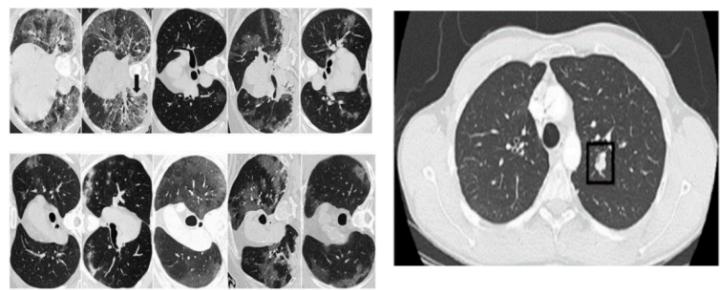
Sample CT Scan from LIDC-IDRI Dataset
